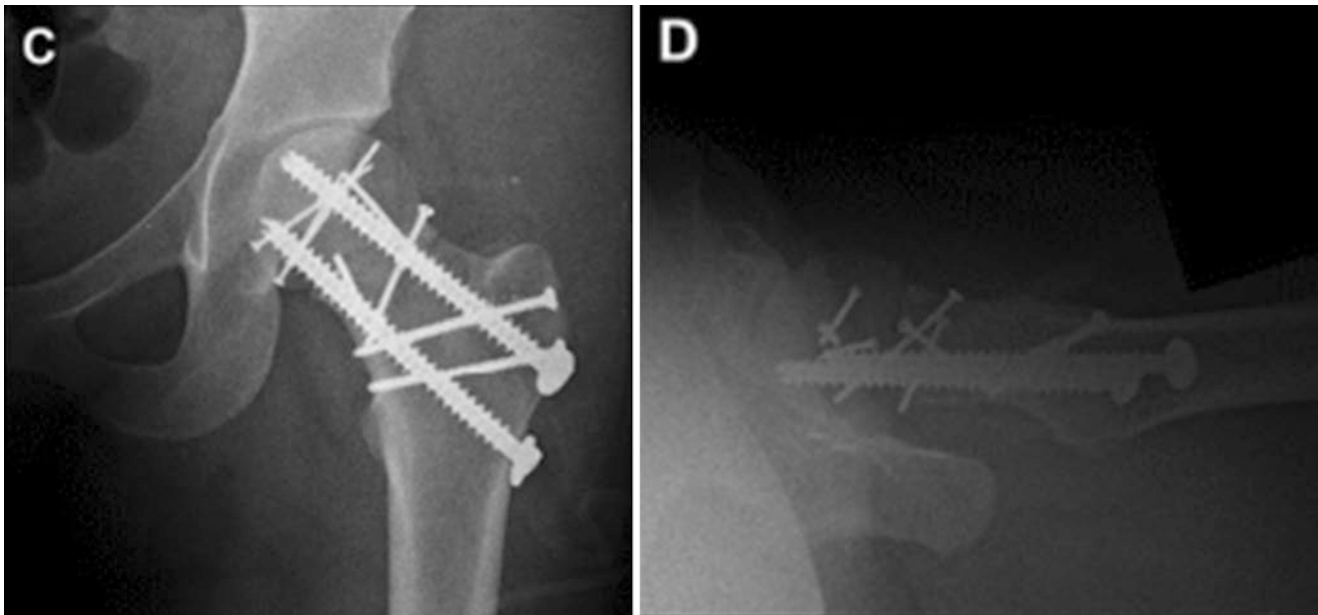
AP and cross-table radiographs of a left-sided femoral head fracture-dislocation with an associated femoral neck fracture treated with cannulated screws for the femoral neck and small-fragment screws for the femoral head (Fig. 1C & 1D in Ross, James R., and Michael
